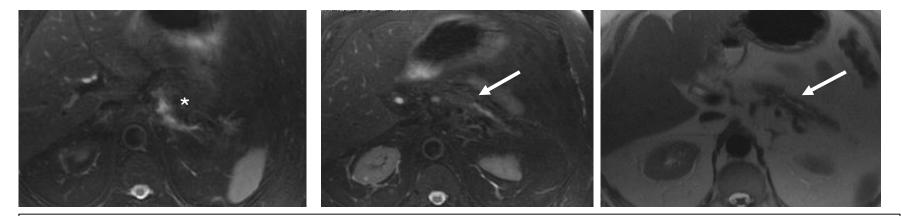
Patient 1. MR axial fat-sat T2, T2* at same time of first CT. Note signs of mild pancreatitis (*) and segmental dilatation of MPD with no evident mass at the MPD stenosis point (arrow). Follow up was recommended.
